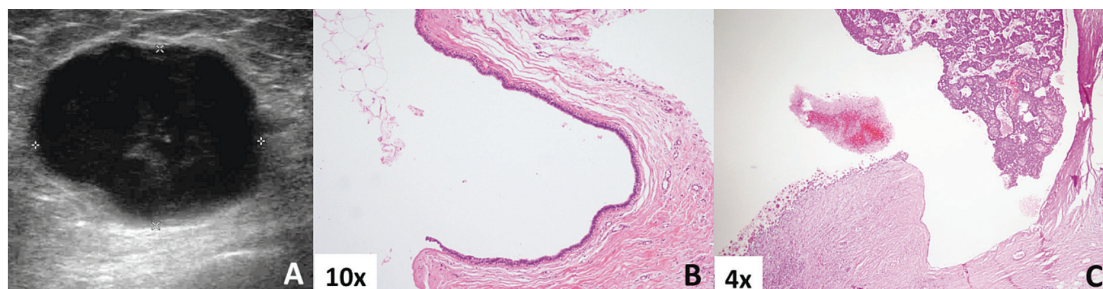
False positive case. A, Ultrasonography revealed irregular hypoechoic nodule. B, CNB; Atypical ductal hyperplasia. C, Open biopsy; Usual ductal hyperplasia without atypical ductal hyperplasia despite further step sections.
